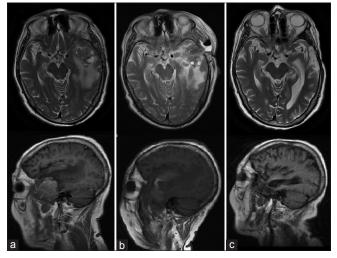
Case 9: (a) magnetic resonance image enhanced in axialT2 and sagittalT1 showing the preablation temporal lesión. (b) Same sequences I month after ablation. (c) Same sequences II months after ablation
